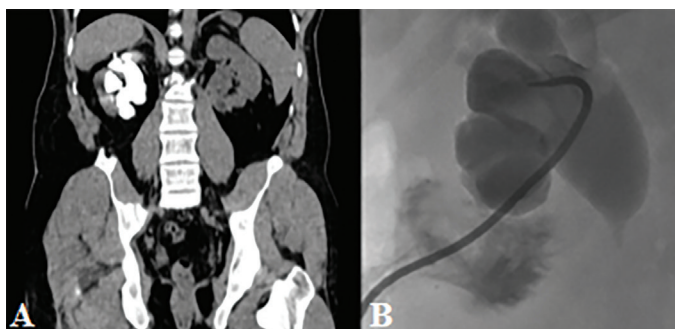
Preoperative computed tomography-nephrostography images of Case 1, revealing the complete obstruction of the ureteropelvic junction. A. Coronal CT image, B. Antegrade pyelography image
